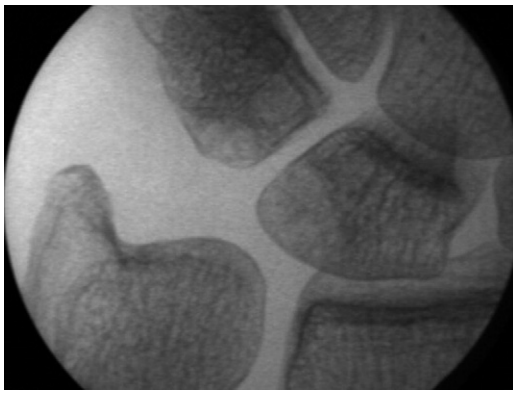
Posteroanterior radiograph of the wrist with subchondral lucency in the proximal ulnar corner of the lunate and the proximal corner of the triquetrum due to ulnar positive variance and ulnar impaction.
